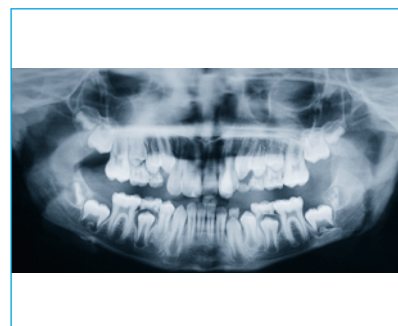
Orthopantomogram taken prior to intra-oral photos showing erupted, unerupted and some primary teeth close to exfoliation. Note presence of 5 incisors in all
